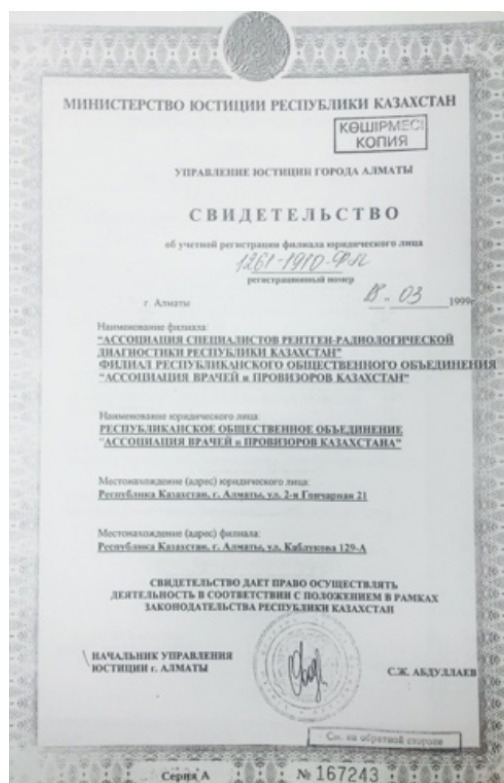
X-ray Radiological Diagnostics of the Republic of Kazakhstan Association's Registration Certificate.*
